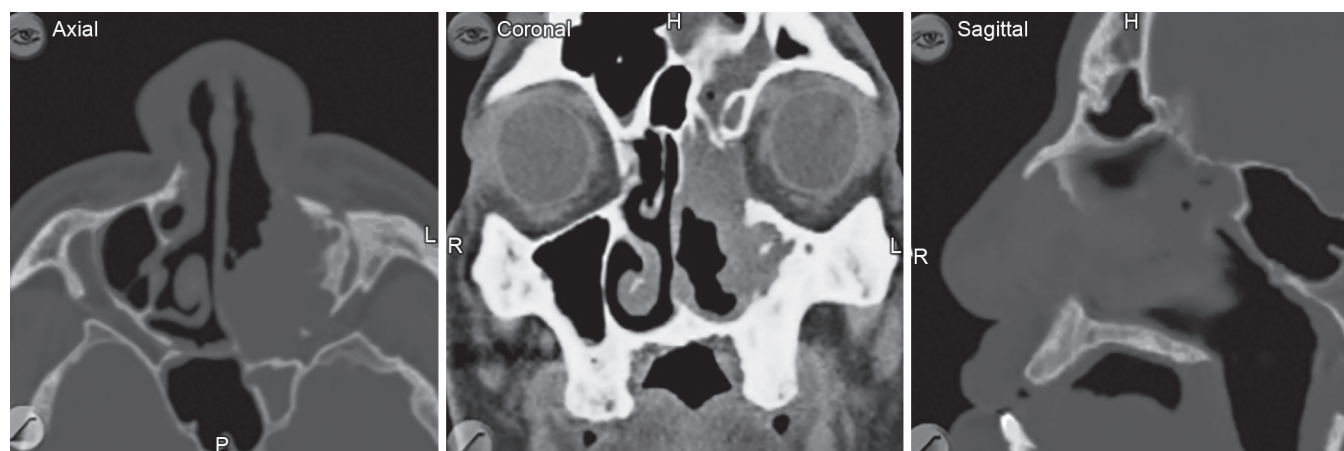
Computed tomographic imaging of an extensive, recurrent left-sided sinonasal inverting papilloma with extension to the skull base and frontal recess. Note the dehiscent left lamina papyracea.
